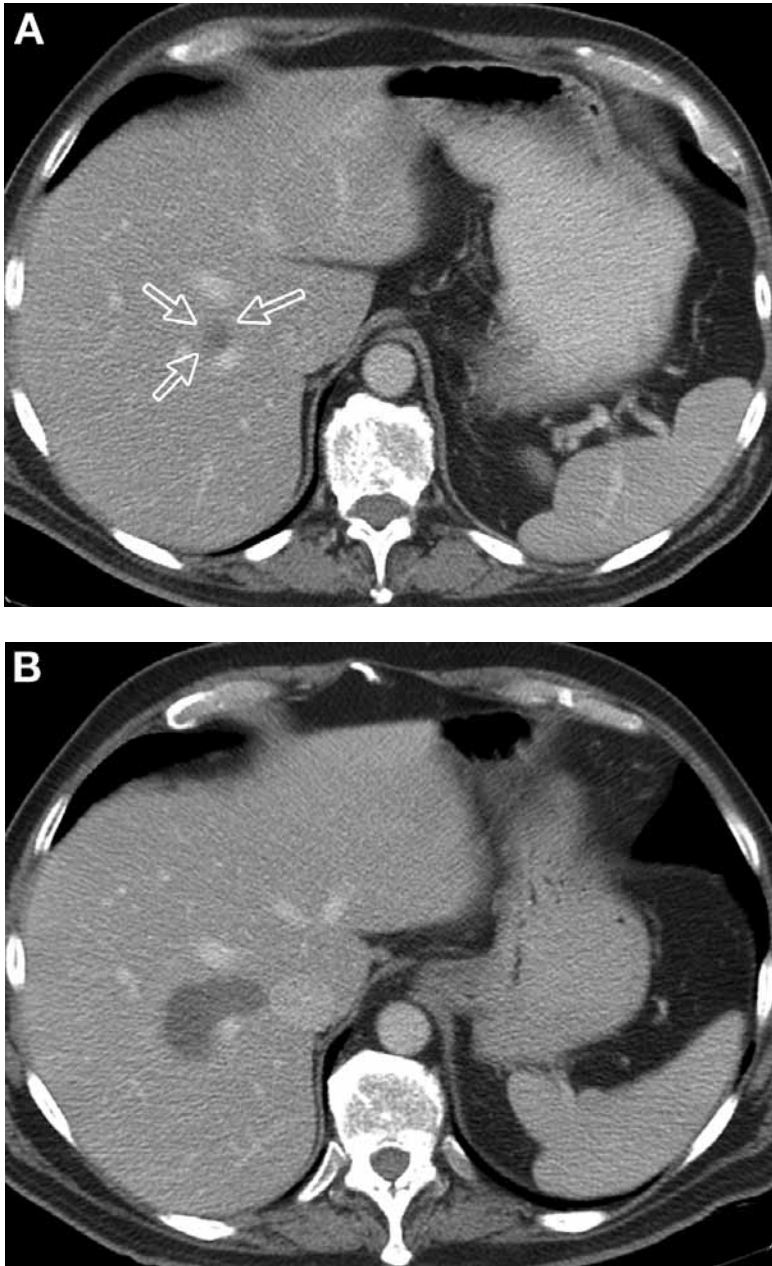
(A) Pre-RFA CT demonstrates a small colorectal metastasis in between the right and middle hepatic veins. The lesion is directly contiguous with right hepatic vein. (B) Post-RFA CT image at same level 6 wk following RFA. The low-density area is larger than the lesion seen on pretreatment scan, and represents the region of ablation.
